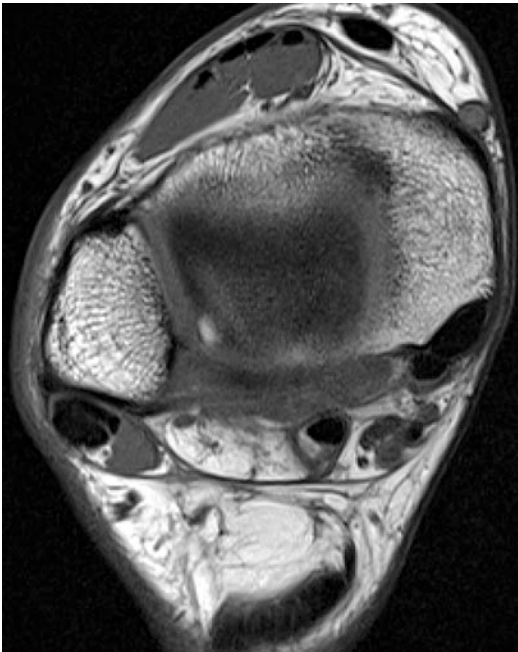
Axial T1-weighted MR image of the foot/ankle, which clearly visualized the achilles tendon
